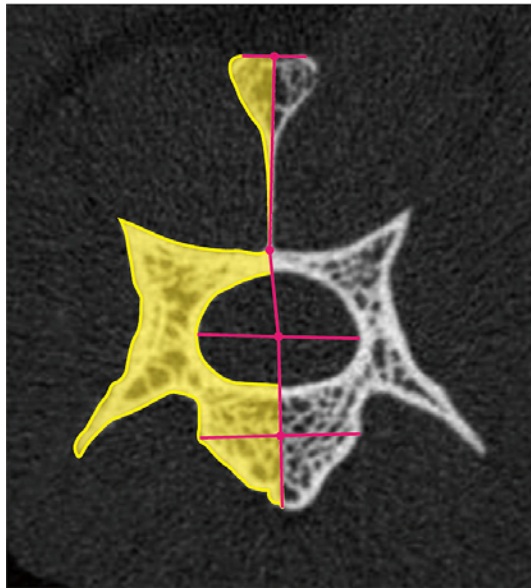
Range of bone volume measurement on CT images. Straight lines were connected between the midpoint of the upper edge and base of the spinous process, between the base of spinous process and the midpoint of the maximum lateral diameter of the spinal canal, and between the midpoint of the maximum lateral diameter and width of the vertebral body. By extending the straight line connecting the midpoint of the maximum diameter of the spinal canal and the midpoint of the vertebral body width, the vertebra was divided into left and right. The same contours were drawn on each side of all slices.
